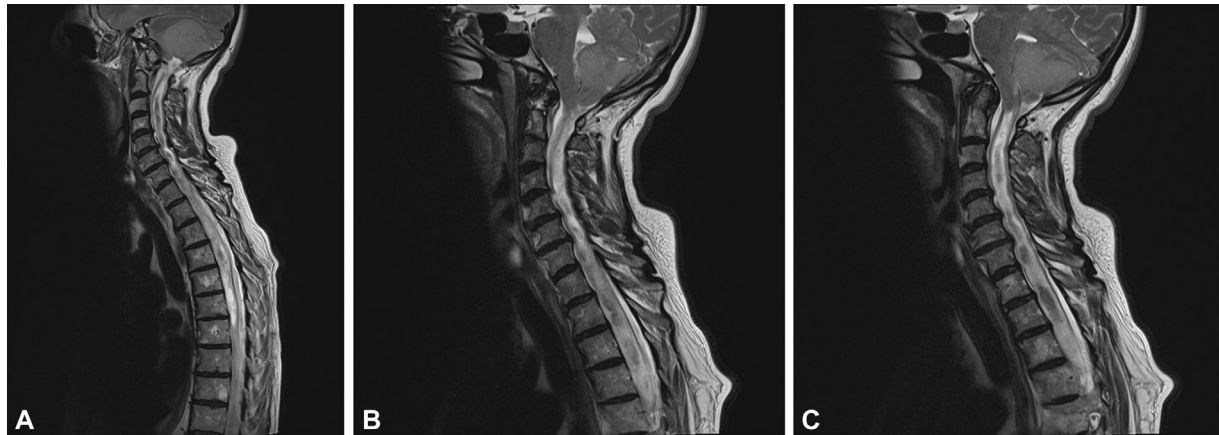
(A–C) T2 sagittal magnetic resonance imaging showing the extent of the cervicothoracic syrinx and the point of tonsillar narrowing at the foramen magnum just cranial to its origin.
